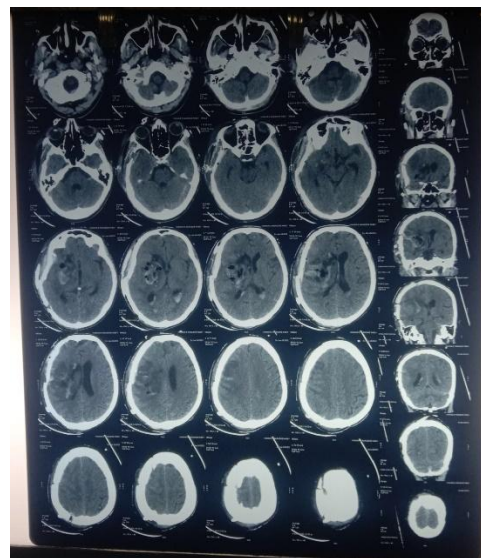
Post op CT scan
